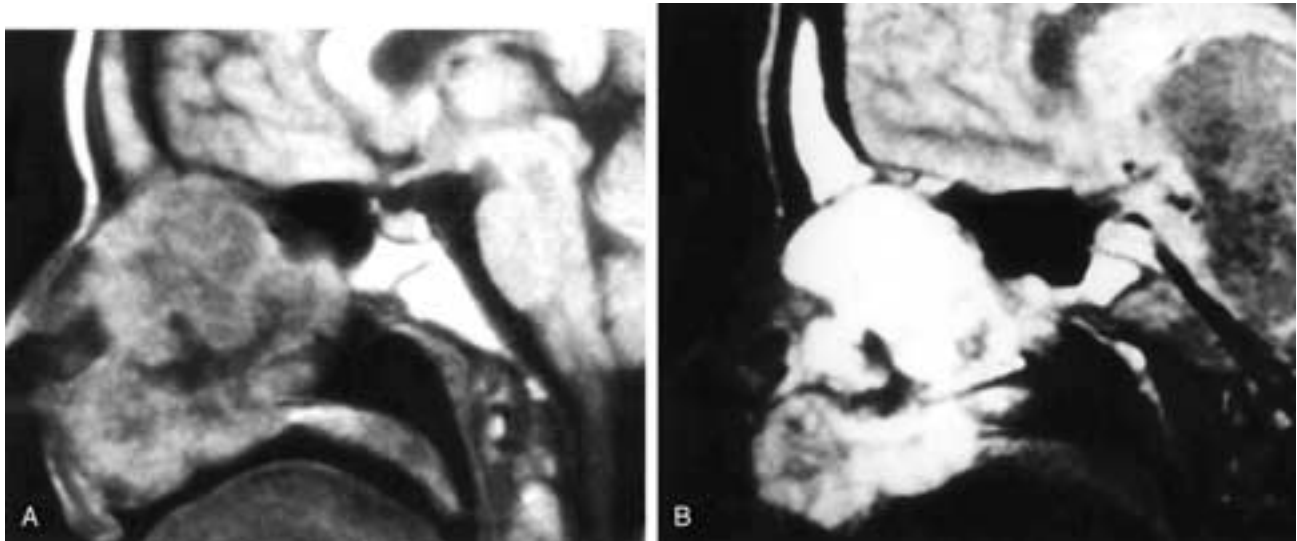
Sagittal T1-weighted (A) and T2-weighted (B) MR images show a slightly nonhomogeneous nasal septal mass that has a low to intermediate signal intensity in A and a high signal intensity in B. The frontal sinuses are obstructed by the tumor. This patient had a chondrosarcoma.
